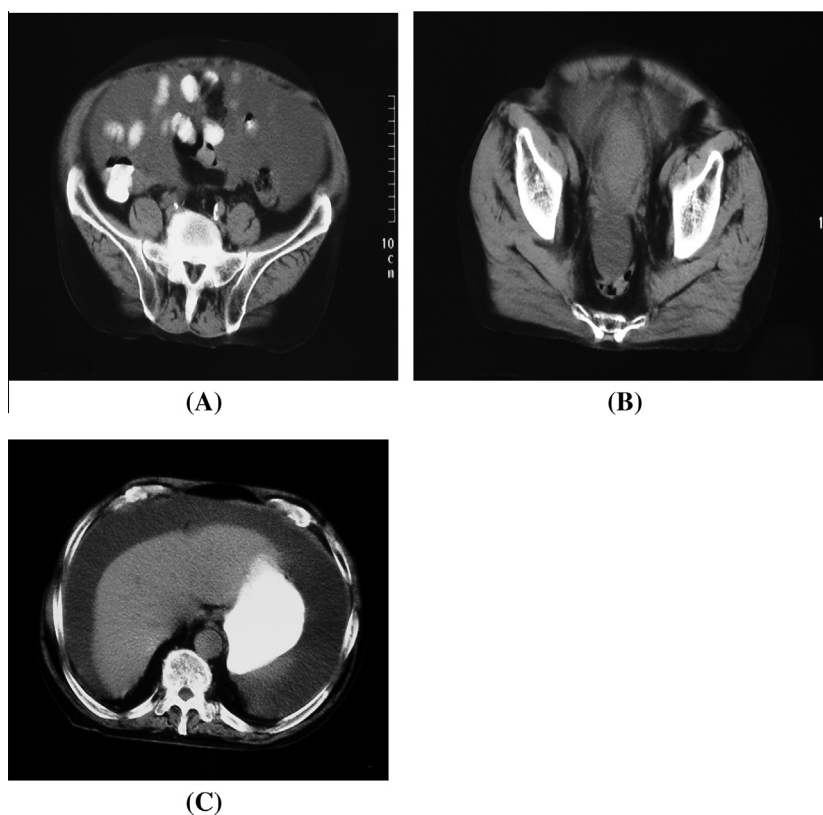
(A) Abdominal CT scan showing peritoneal/omental thickening, (B) enlarged prostate gland and (C) ascites.
